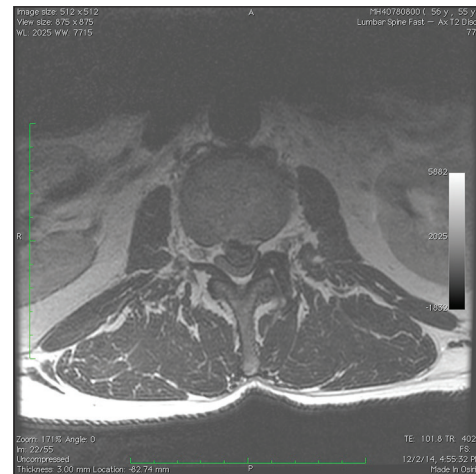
The preoperative December 2014 magnetic resonance imaging axial study documented a massive central-left sided L2–L3 disk herniation resulting in severe thecal sac and left L2 and L3 foraminal/lateral recess root compression respectively
